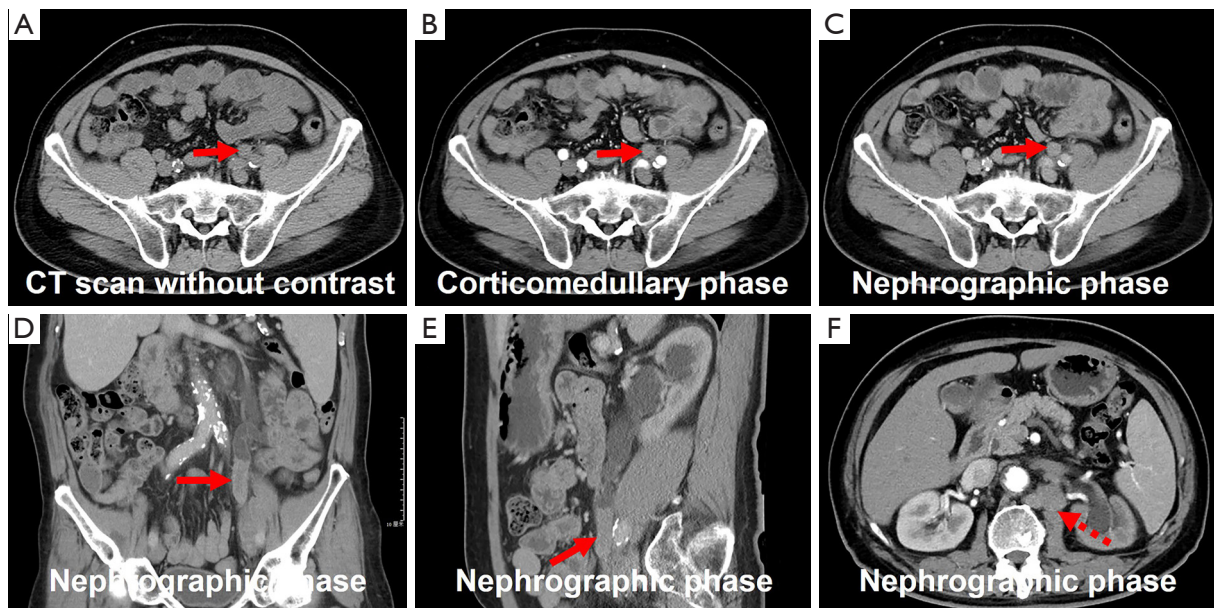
Computed tomography urography imaging of ureteral DSRCT. (A-C) Transverse images revealed a soft tissue density mass restricted to the lumen of the left mid-ureter (long arrows), with a CT attenuation value of 42 HU in the plain phase and 73 and 70 HU in the corticomedullary and nephrographic phases, respectively. (D,E) Coronal and sagittal images from the nephrographic phase revealed the lesion (long arrows) to be striated and measuring approximately 1.20 cm at its widest point, with an area of involvement estimated at around 4.10 cm; enhancement scans displayed moderate enhancement. (F) Transverse images revealed the presence of enlarged lymph nodes adjacent to the abdominal aorta (dashed arrow). CT, computed tomography; DSRCT, desmoplastic small round cell tumor; HU, Hounsfield unit.
